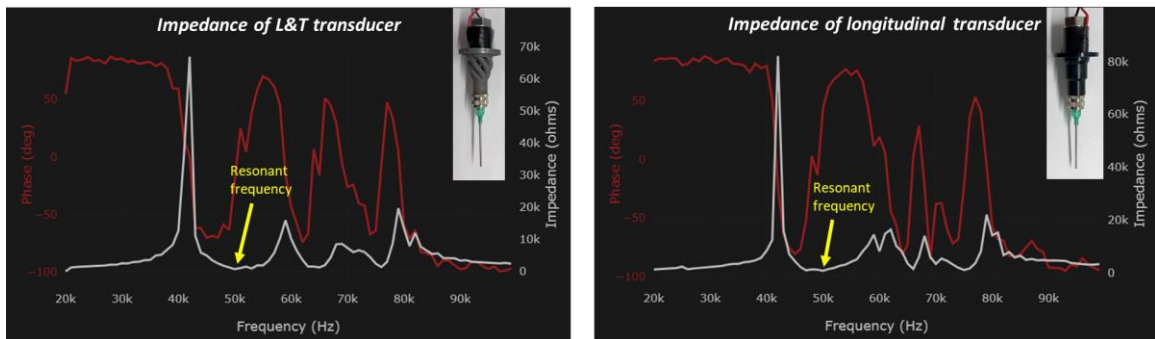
Impedance analysis of L&T ultrasonic transducer and longitudinal transducer.
